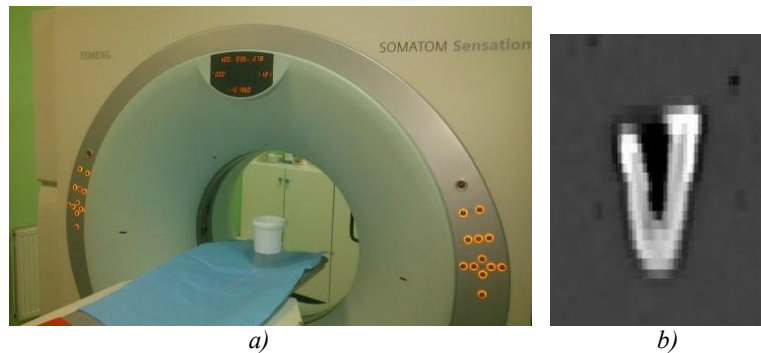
CT scanning a) master model placed on CT device, b) one tomogram of scanned tooth
